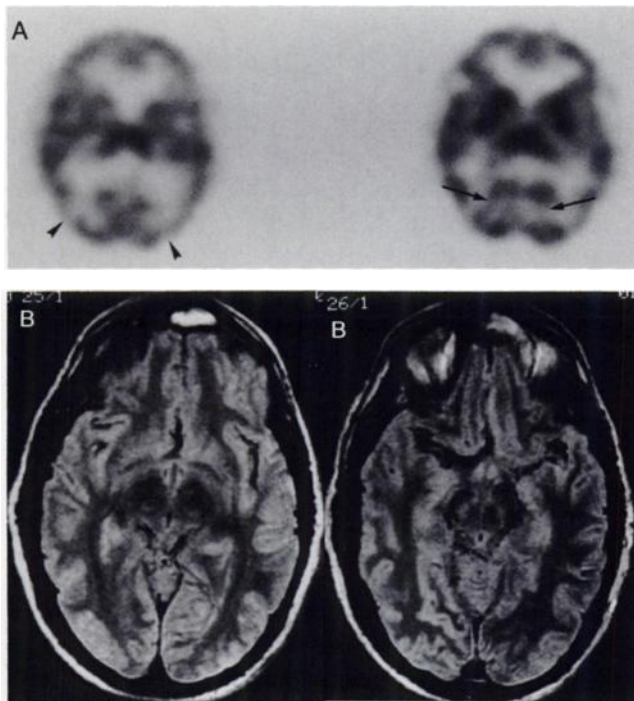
SPECT and MRI of Patient 4, who suffered visual agnosia and bilateral inferior altitudinal field loss following a posterior-lateral myocardial infarction and cardiac arrest. (A) SPECT detected bilateral posterior hypoperfusion in the visual cortex anterior to the occipital pole (arrows) as well as some minor hypoperfusion of the lateral occipital lobes (arrowheads). (B) MRI is normal. SPECT was more diagnostic than MRI for this patient's visual difficulties.
